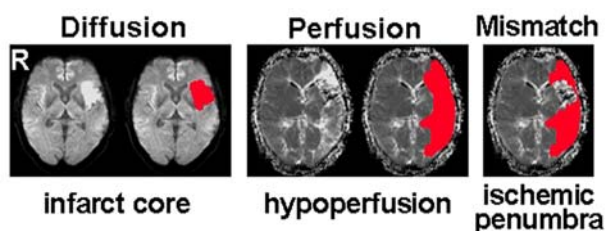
An example of DWI, DSC-PWI and PWI/DWI-mismatch area.
